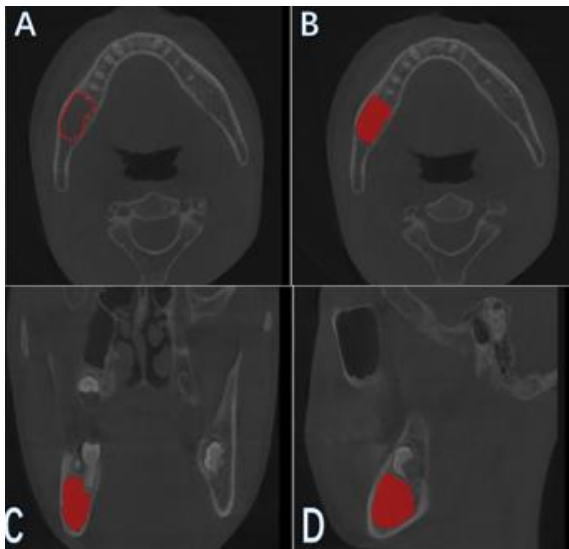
The results of area of interest (ROI) segmentation from CBCT images. (A) A ROI was manually delineated from CBCT images, (B) Axial plane, (C) Coronal plane and (D) Sagittal plane. The cyst is marked in red [10].
